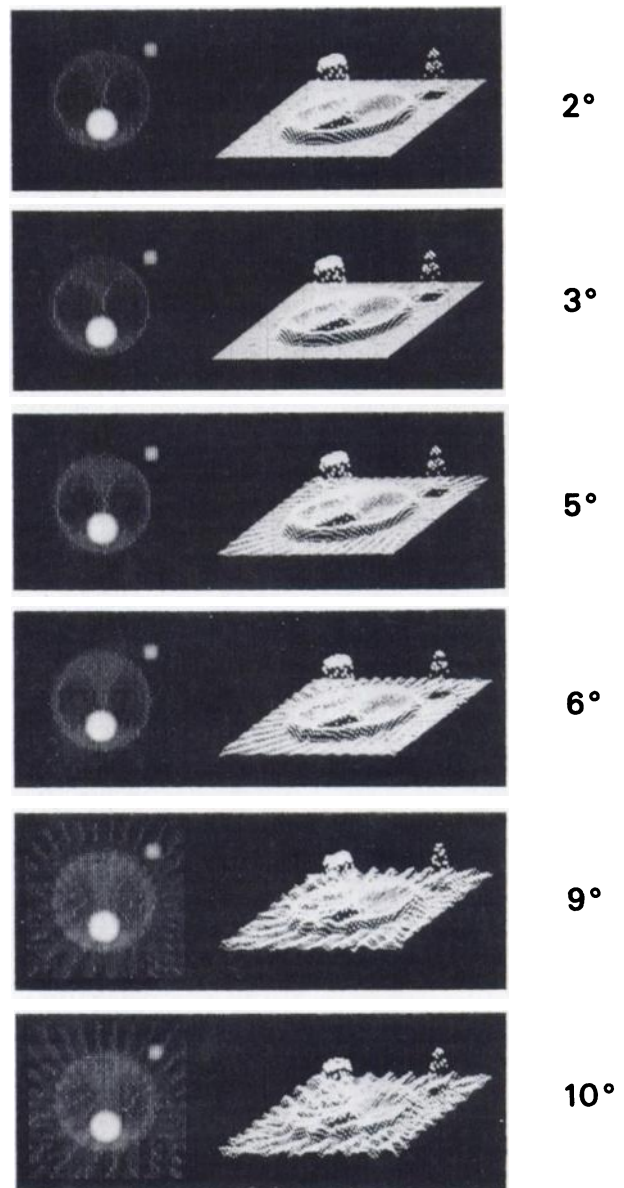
Number of angular views necessary for 360° coverage in transverse section computed tomography is approximately equal to number of resolution elements across image. In this case for 64 resolution elements across image, aliasing artifact accompanying coarsely sampled data disappears for sampling with less than 5° increments.
